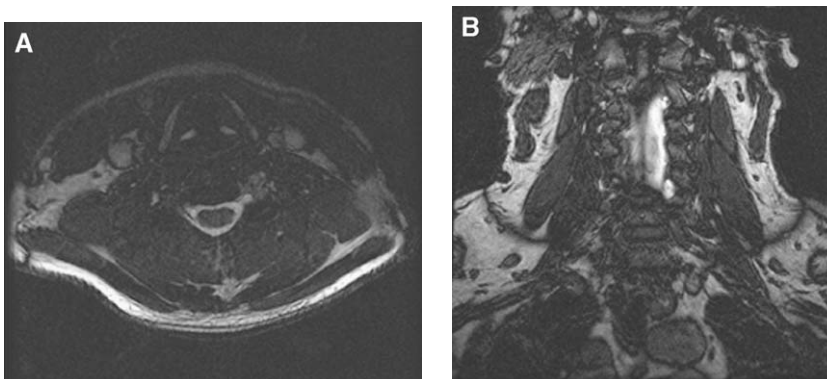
(A and B) Axial and coronal high-resolution heavily T2-weighted images (FIESTA sequence) reveal a small pseudomeningocele in the left neural foramen and absence of the traversing nerve root, indicative of a nerve root avulsion.
